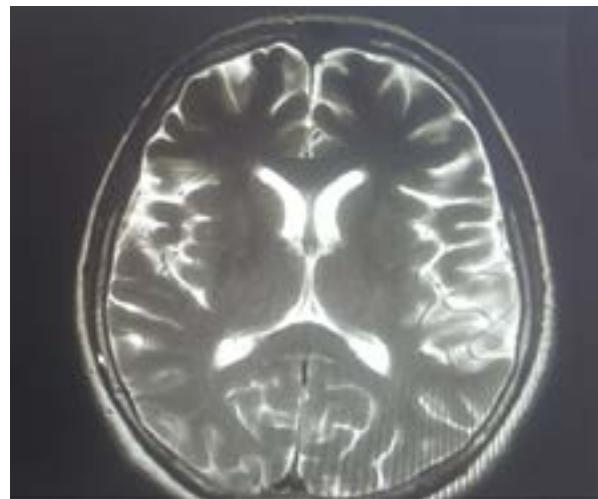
Changes in MRI examination
